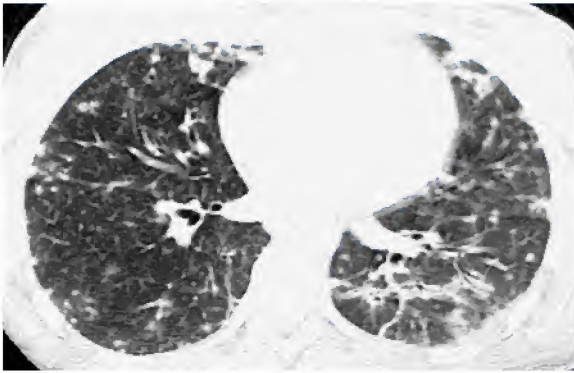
Human metapneumovirus pneumonia in a 58-year-old man with neutropenia following HSC transplantation. Transverse thin-section (1-mm collimation) CT scan obtained at level of the carina shows bilateral areas of ground-glass attenuation and multiple ill-defined nodules affecting the posterior segment of the right upper lobe and both superior segments of the lower lobes
